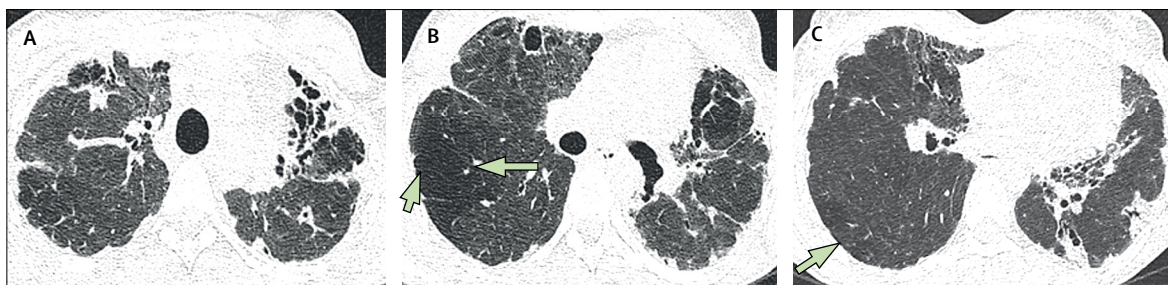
CT pattern most consistent with non-IPF diagnosis
